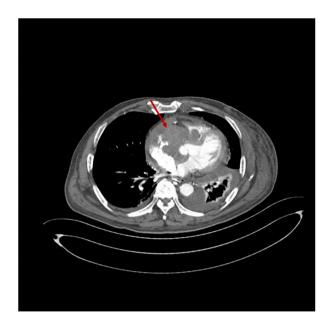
Enhanced CT scan of the right heart. As indicated by the arrows, the CT scan shows an irregular morphology of the right side of the heart with a mass observed and enhancement of the right auricle, right atrium and ventricle regions.. CT, computed tomography.
